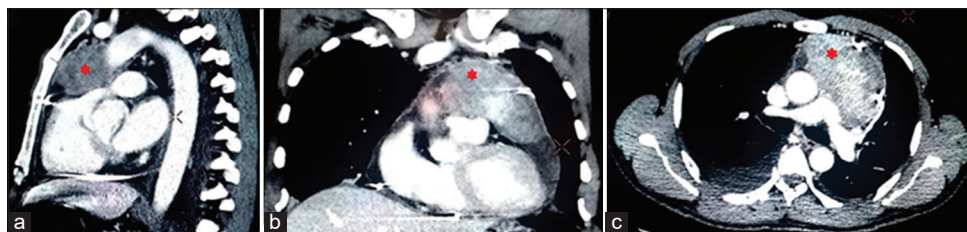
Computed tomography images of thorax in sagittal (a), coronal (b), and cross section (c) views, showing heterogeneously enhancing mass lesion (red stars) in anterior mediastinum in relation to origin of great vessels and extending into pericardial cavity. Pericardial and pleural effusion, along with pericardial drainage catheter noted
